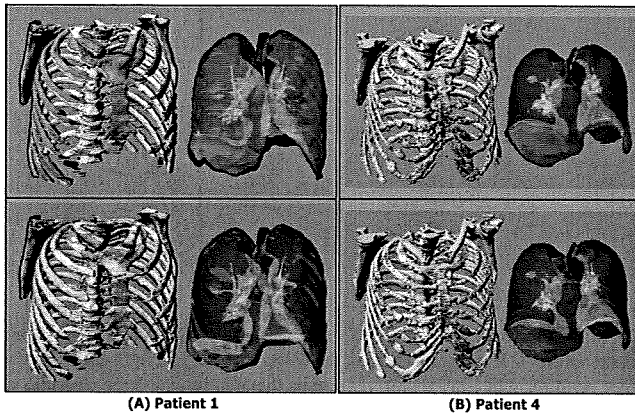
Visual evaluation of virtual CT images created using the 3D+ algorithm with respect to bones and lungs, by 3D surface-rendering images for the worse (patient 1) and best (patient 4) cases. The upper row compares the end-exhale 4D-CT and end-inhale virtual CT images; the lower row compares the actual 4D-CT and virtual CT images at end-inhale. Red regions indicate areas of structural mismatch between the two images.
